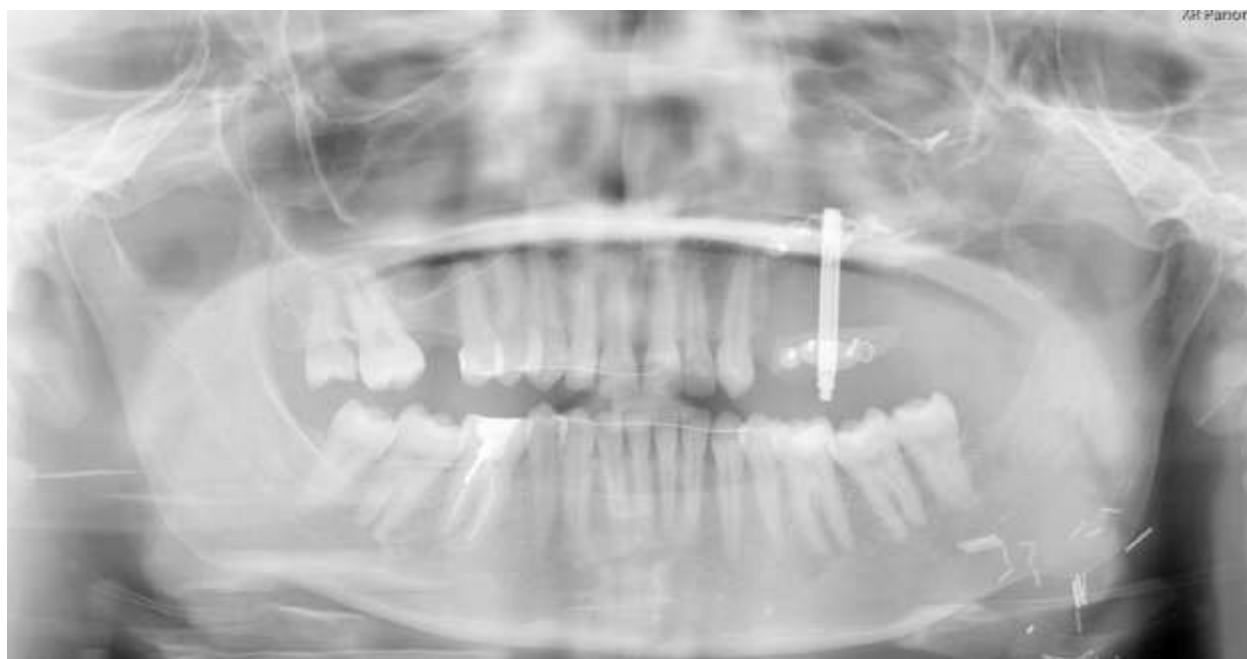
Panoramic radiograph showing vertical distraction device in situ over fibula free flap. The distractor is clearly visualized, demonstrating its alignment and integration with the grafted segment for vertical osteogenesis.
